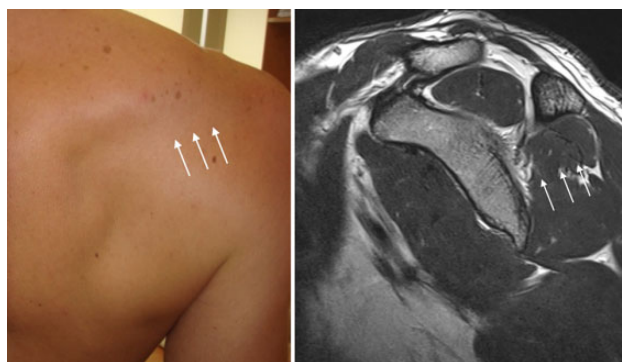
Photograph showing ISP 50 months postoperatively and corresponding sagittal view on postoperative magnetic resonance imaging scan. White arrows indicate regeneration of ISP. ISP, infraspinatus.
